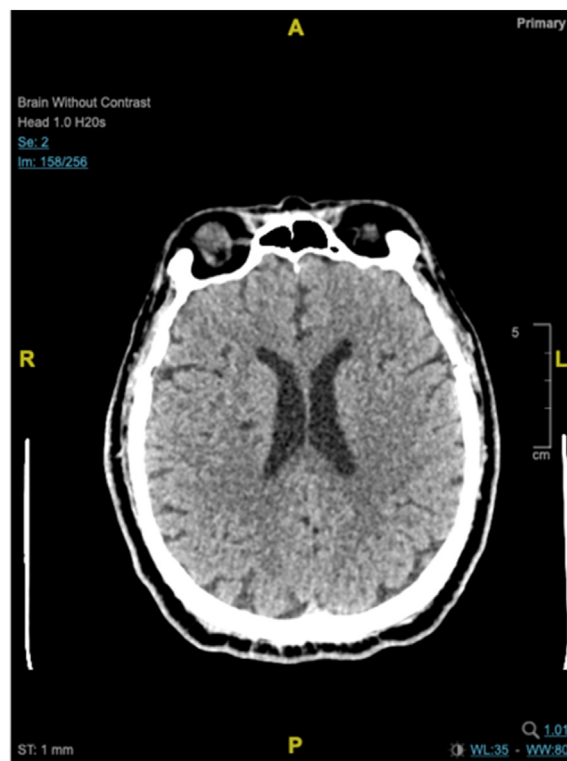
A repeat brain CT at Day 4 post trauma, showing no evidence of any new evolution of stroke or haemorrhagic transformation.
